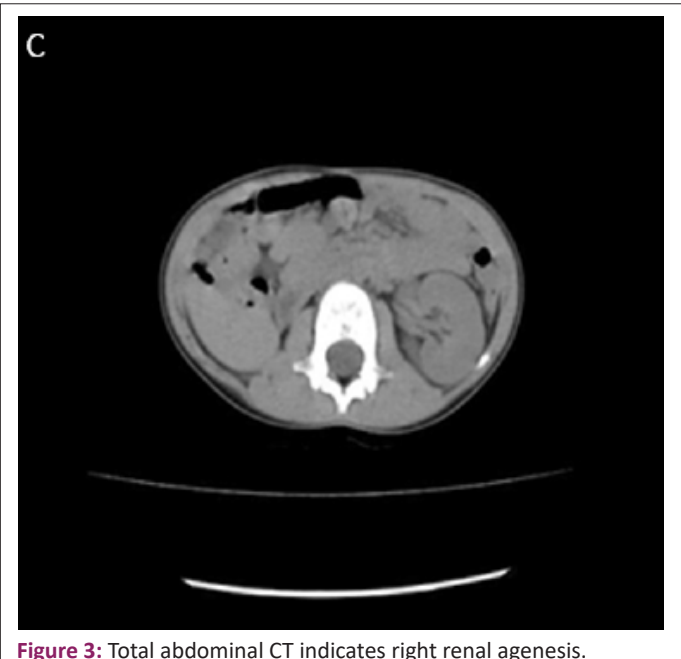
Total abdominal CT indicates right renal agenesis.
